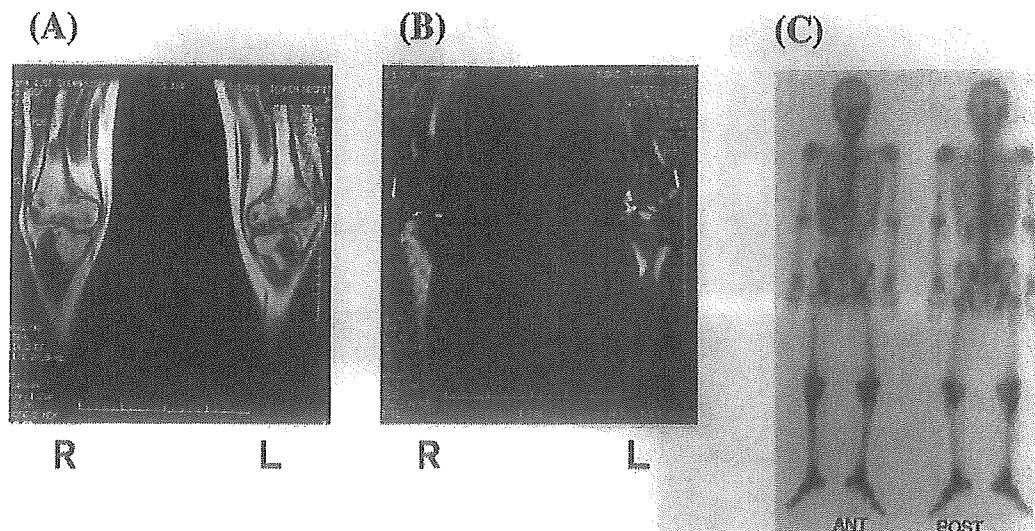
MRI (A: T1-weighted, B: T2-weighted) and ^{67}Ga scintigraphy (C) findings of multiple bone metastases
